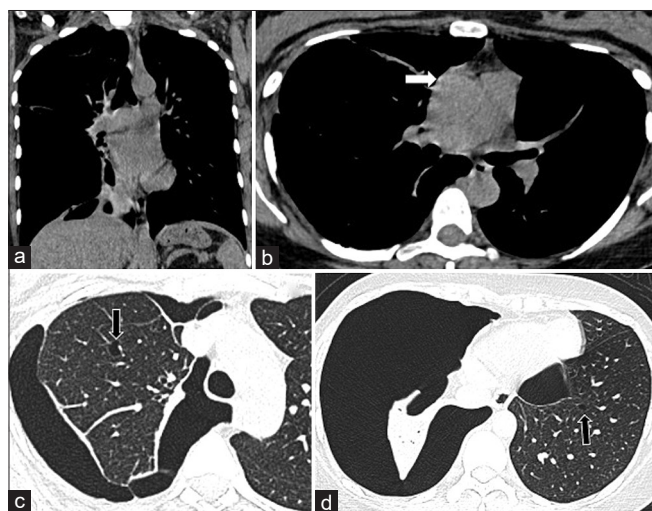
(a-d): 32-year-old female with mediastinal window coronal (a) and axial (b) sections showing no pleural effusion, pleural thickening or mediastinal lymphadenopathy. (c) and (d) Lung window axial sections showing multiple small lung cysts with thin walls (arrows) and gross right pneumothorax and loculated left pneumothorax. No consolidation or solid component seen. CT-PECS score for this case is zero and hence classified as noninfectious cause of pneumothorax
